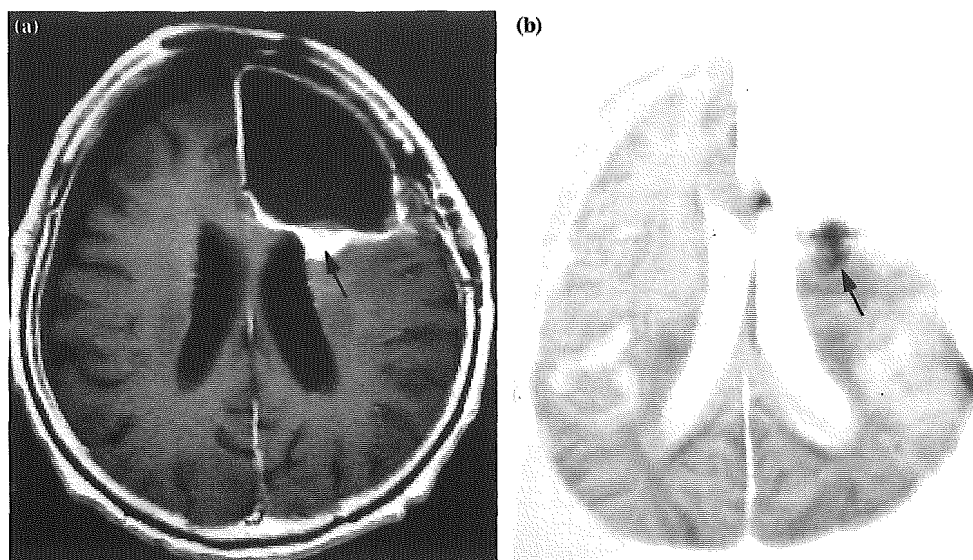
Conventional MRI and 3DAC of Case 7 at recurrence. (a) Gd-T1WI shows markedly enhanced mass suggesting recurrent glioblastoma in the anterior corona radiata, corresponding to the slightly darkened area in Figure 3C (arrow). (b) Recurrent glioblastoma shown as enhancement on Gd-T1WI appears black on 3DAC (arrow).
